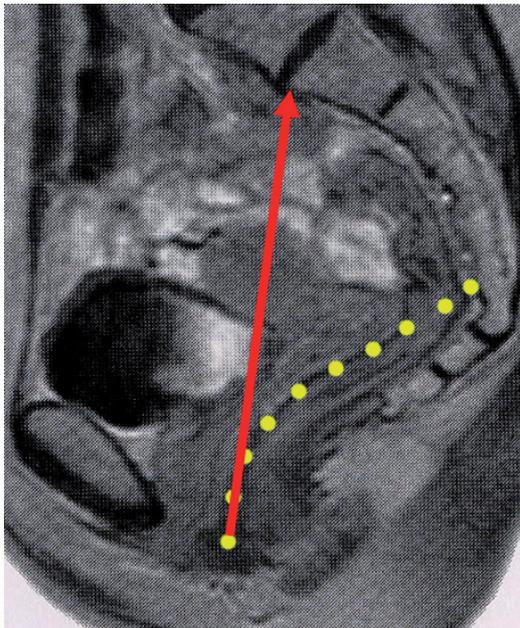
MRI – Picture of the female pelvis in upright position. Sagittal view of pelvic organs. Dotted yellow line = normal axis of vagina in a banana shaped backwards curve. Red arrow = unphysiological vertical unbowed axis of vagina after laparoscopic/laparotomic sacrocolpopexy.
